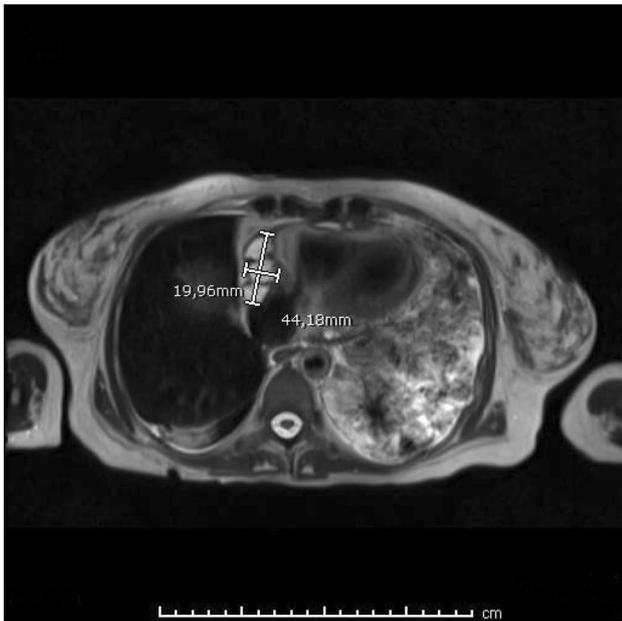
T2-weighted image without intravenous contrast show hyperintense pericardial lesion suggestive for fluid collection
